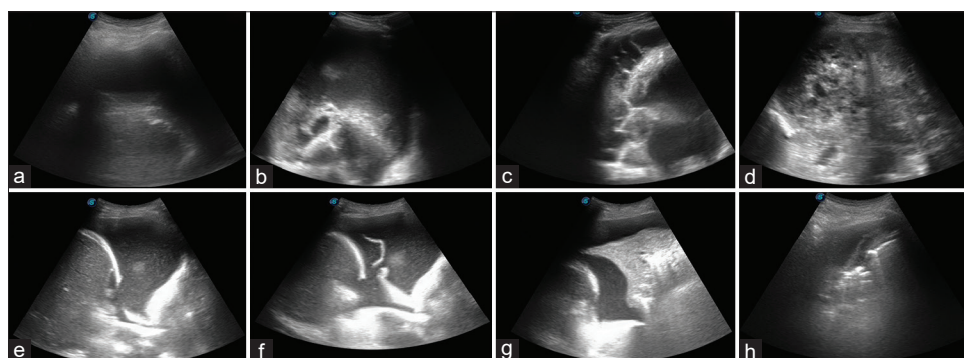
(a) Anechoic sonographic pattern, (b) Hyperechogenic sonographic pattern, (c) Complex septa-free sonographic pattern, (d) Complex septal sonographic pattern, (e) Presence of snowy landscape appearance, (f) Presence of fibrin band in the fluid, (g) Presence of consolidated lung space in the fluid, (h) Presence of atelectatic lung area.
